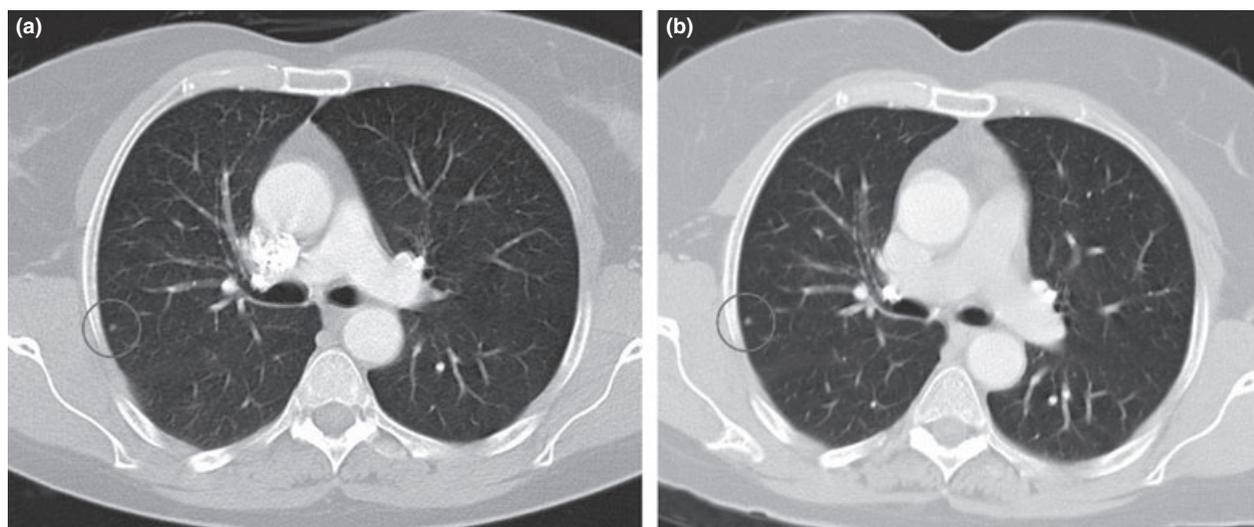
Patient no. 3 showed in the contrast-enhanced CT 42 days prior to DDLT (a–lung window, high resolution kernel, 8-mm slice thickness) two very small lesions in the right middle and lower lobe, each with 2-mm diameter and nonsolid density. The control CT 6 months post-LT (b–lung window, high resolution kernel, 5-mm slice thickness) showed multiple new intrapulmonary metastases in both lungs, but the initially found two lesions unchanged.
